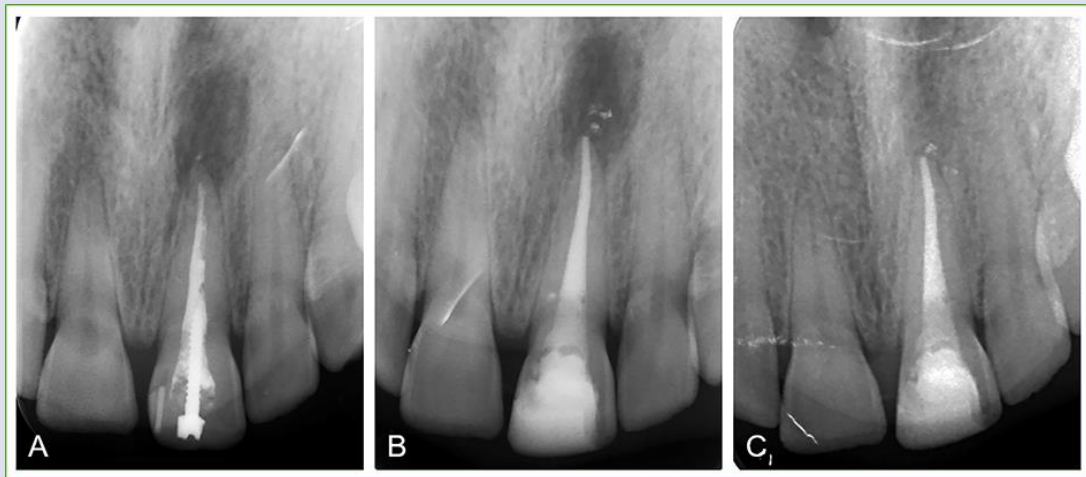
Radiographic evaluation of a case. (A) diagnostic periapical radiograph, PAI 4 (B) periapical radiography taken immediately after retreatment, PAI 4 (C) 1-year follow-up periapical radiograph, PAI 1.
